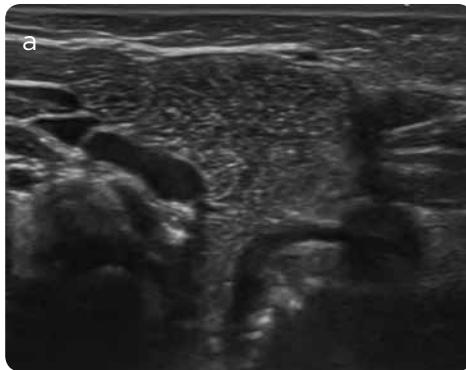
a) Ultrasound mode B: a well-defined, hypo-echoic mass is identified, with small septa in its interior, linear, thin and echogenic. b) Mass with flow after color Doppler exploration.
